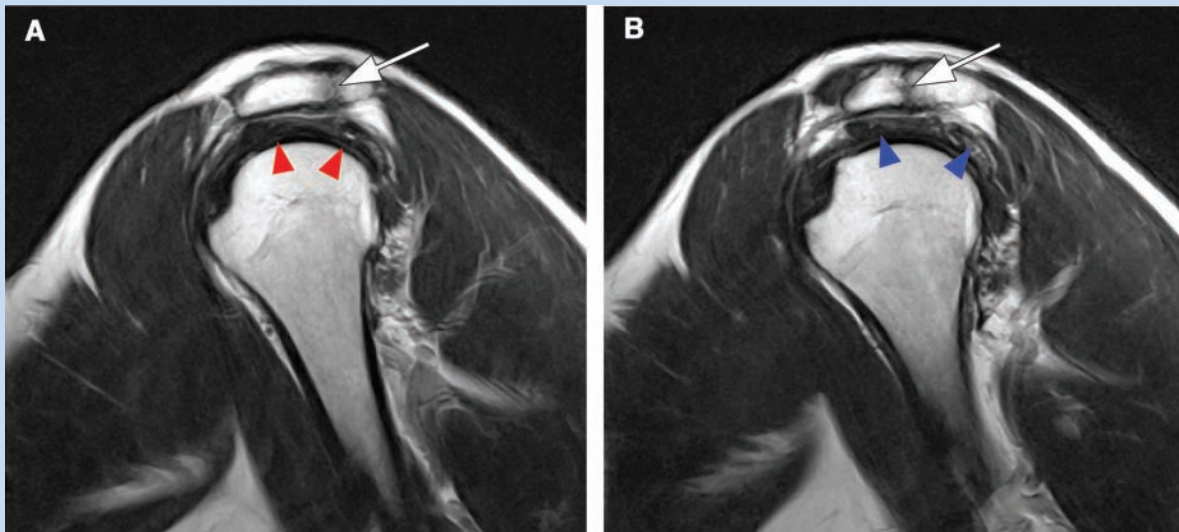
The os acromiale (arrow; A), although it resembles an acromioclavicular joint, is seen to lie at a point both posterior and lateral to it (arrow; B) on T2-weighted sagittal views. Note that the os acromiale is visible on lateral images where the rotator cuff tendons are continuous (red arrowheads) whereas the acromioclavicular joint lies at the level of the musculotendinous junction of the cuff (blue arrowheads).
